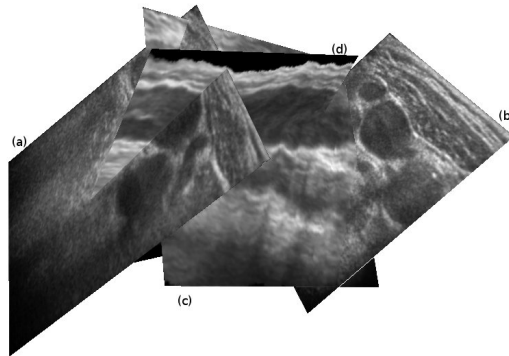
Examples for spatially related ultrasound images from the neck: Original axial slices (a+b) and longitudinal MPRs (c+d) using our reconstruction technique.
